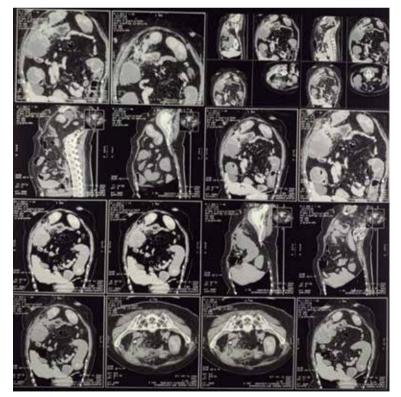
Abdominal CT scan showing a cecal tumor that could be confused with an abscess due to acute appendicitis.
